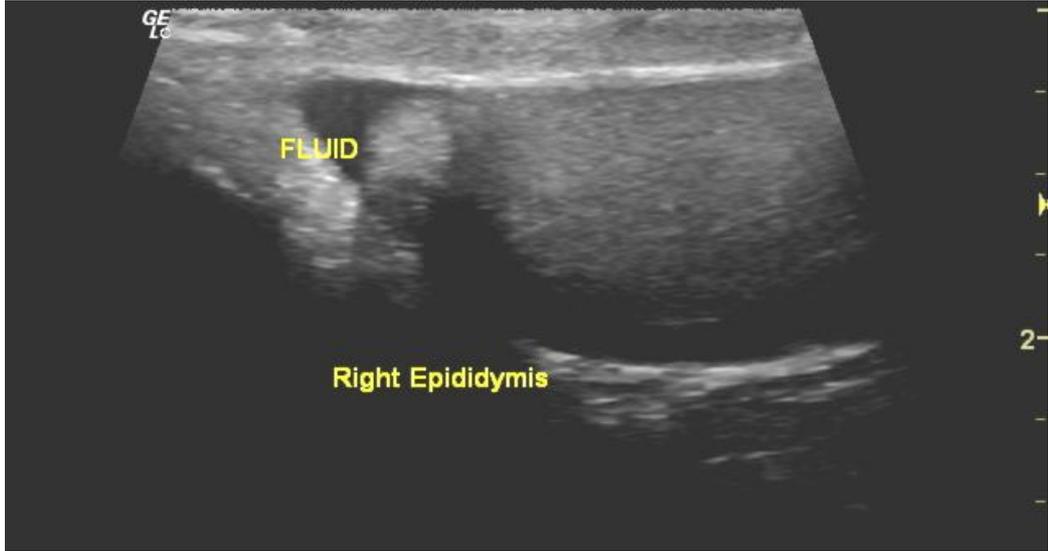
Image of ultrasound scanning of epididymis with fluid accumulation.
